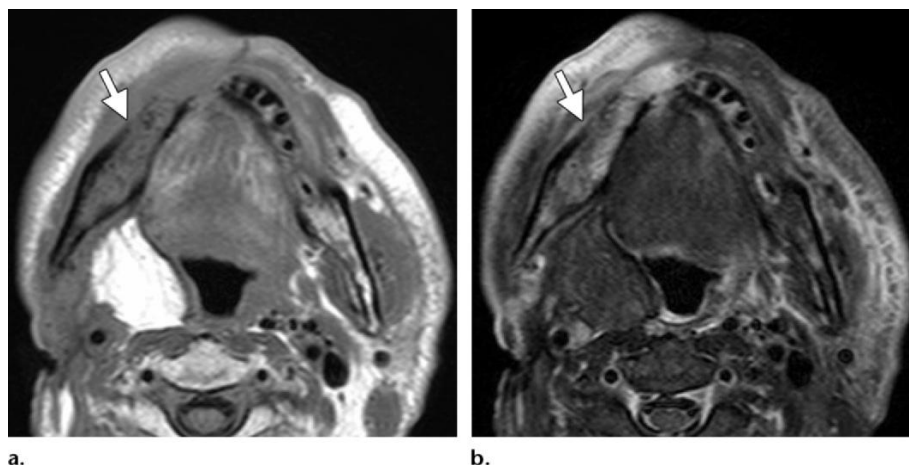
Osteoradionecrosis of the mandible in a 70-year-old man with squamous cell carcinoma of the right tonsil. Tumor resection, right oropharyngeal reconstruction with a rectus abdominis myocutaneous free flap, and radiation therapy were performed. Axial T1-weighted (a) and fat-saturated T2-weighted (b) MR images show a T1-hypointense and heterogeneously slightly T2-hyperintense area (arrow) in the right mandibular body.
